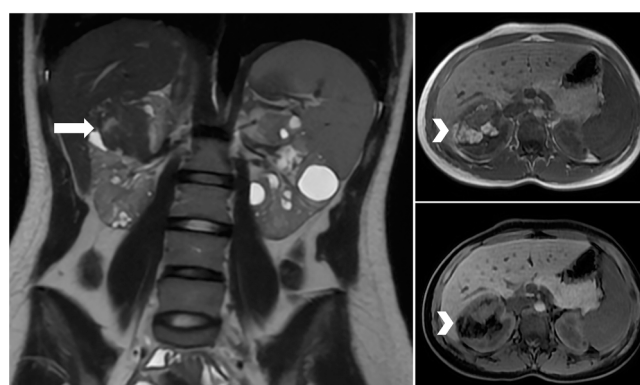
Abdominal magnetic resonance imaging: coronal T2-weighted image reveals multiple simple cystic lesions in both kidneys. A mixed-signal right upper pole mass is also identified (arrow). Transverse T1 and fat-suppressed T1 images reveal fat content in the right upper pole lesion, appearing in bright signal on T1 and disappearing on fat suppression (arrowheads).
